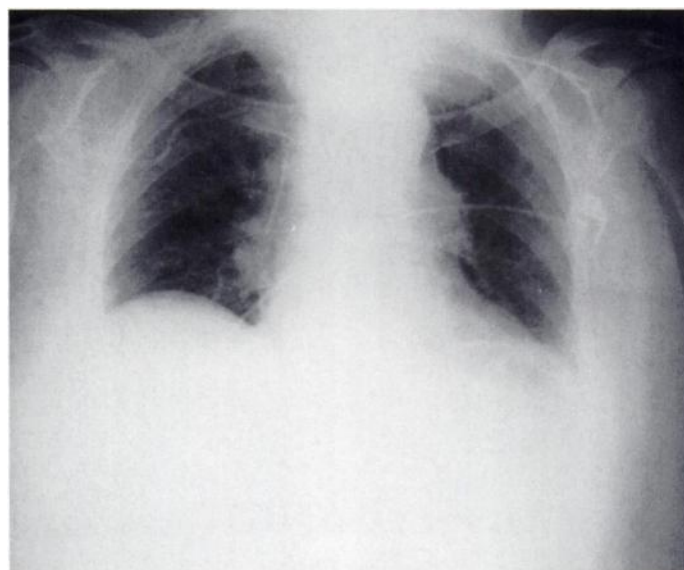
Portable chest radiograph showing underaeration, prominent hila and a right central line in the superior vena cava.
